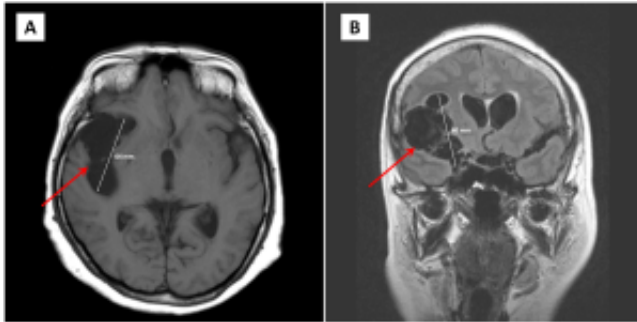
Giant subarachnoid racemose neurocysticercosis. Brain MRI in axial T1 (A) and coronal FLAIR (B) sequences, with occupation of the right Sylvian fissure by multiple cystic images (red arrows)
